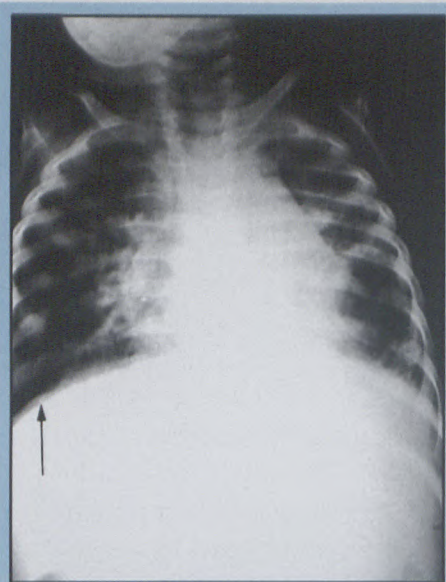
Chest radiograph two months after commencement of therapy demonstrating partial clearing of lung opacification and small fleck of calcification (arrow) on the right diaphragmatic pleura.
